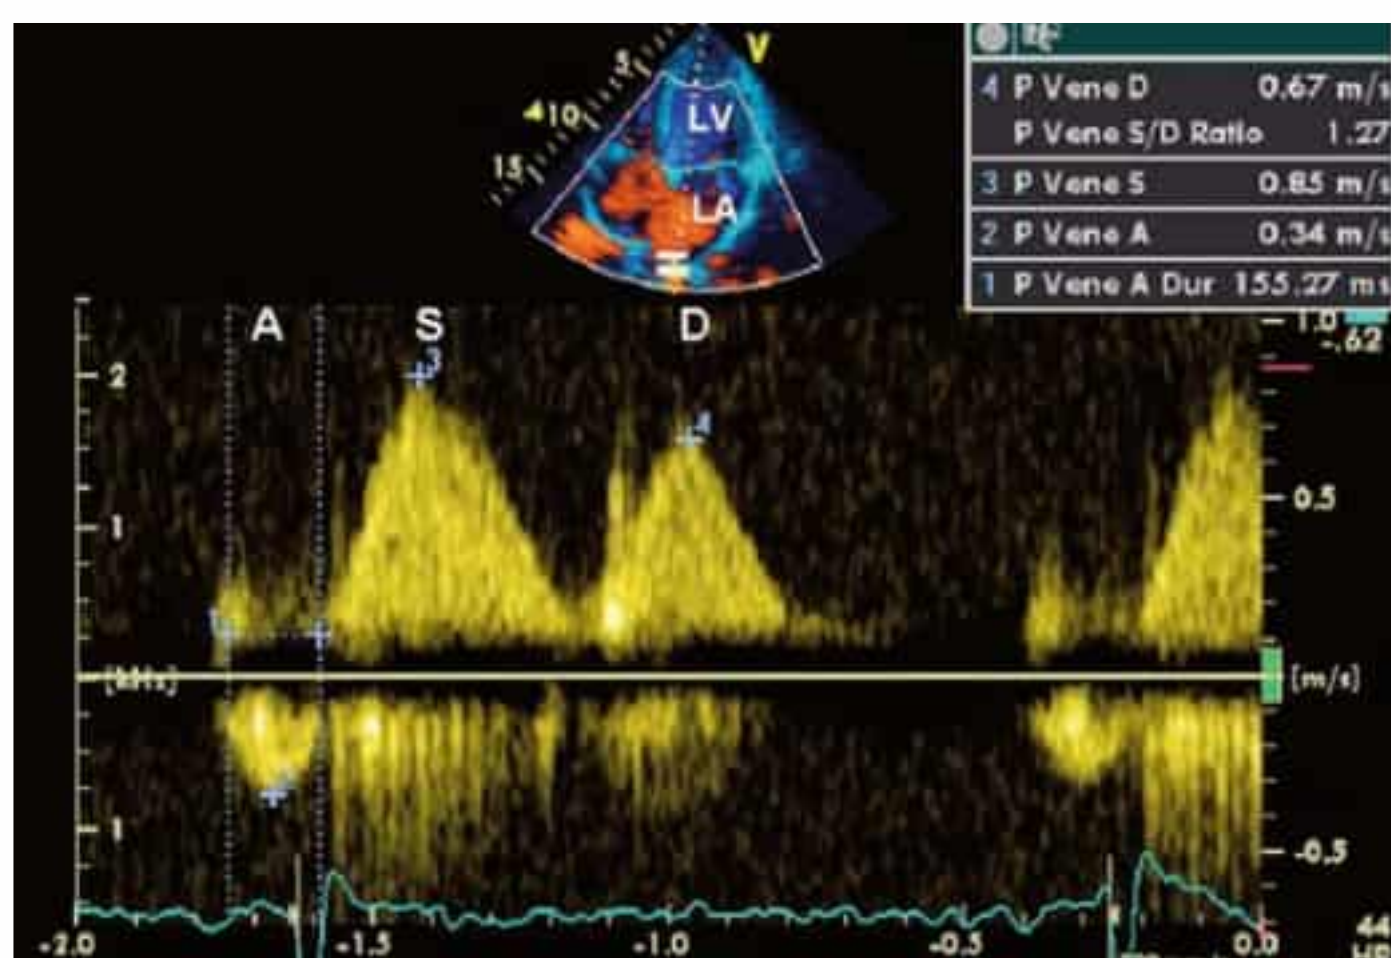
Pulsed Doppler spectrum from the pulmonary veins (PV) shows a normal S-wave amplitude in systole that is higher than the D wave in diastole and a retrograde A wave that is <20 cm/s and is shorter than the A wave in pulsed Doppler of mitral inflow.
